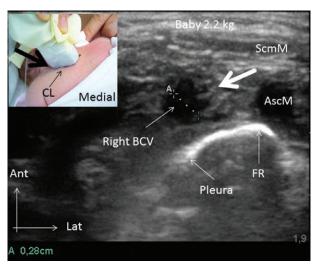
Ultrasonographic long-axis view of the right BCV presenting a circular appearance as the initial part of the BCV in a 2.2-kg infant. *Small picture:* ultrasound probe placed in the right supraclavicular region so as to obtain the optimum long-axis view of the right BCV. *Black, boldfaced arrow* indicates the direction of iv cannula insertion. *Ultrasound image: white, boldfaced arrow* indicates iv cannula entry. A indicates diameter of the BCV, 2.8 mm. Ant = anterior; AscM = anterior scalene muscle; BCV = brachiocephalic vein; CI = clavicle; FR = first rib; Lat = lateral; ScmM = sternocleidomastoid muscle.
